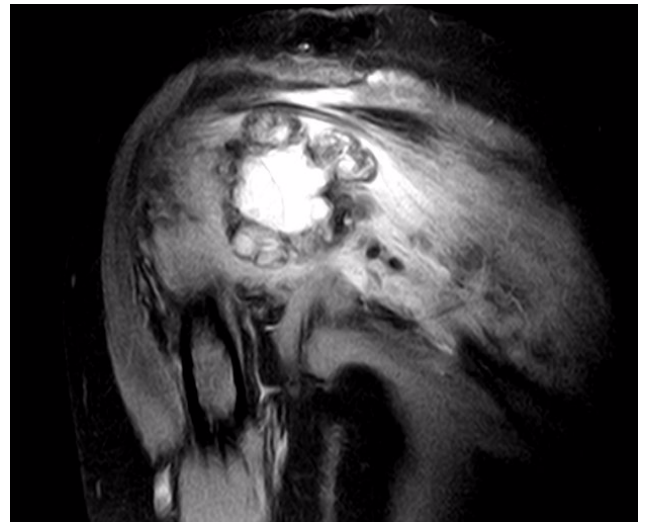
MRI T2-weighted image of left humerus at 3 months follow-up.
